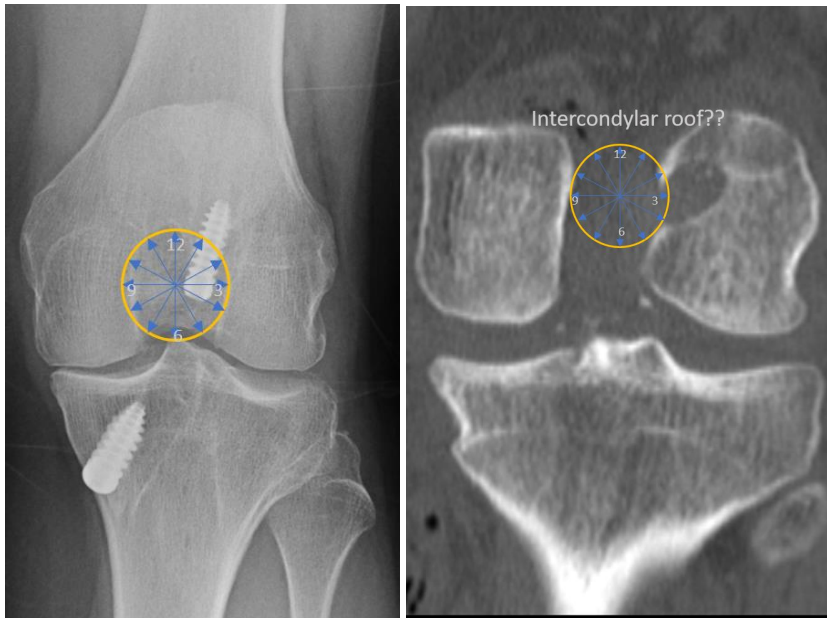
Superimposed clockface on a radiograph performed in full extension. b The clock face on a CT coronal view in full extension. The intercondylar roof is not seen in the same image as the tunnel opening, making the use of the clock face difficult.
